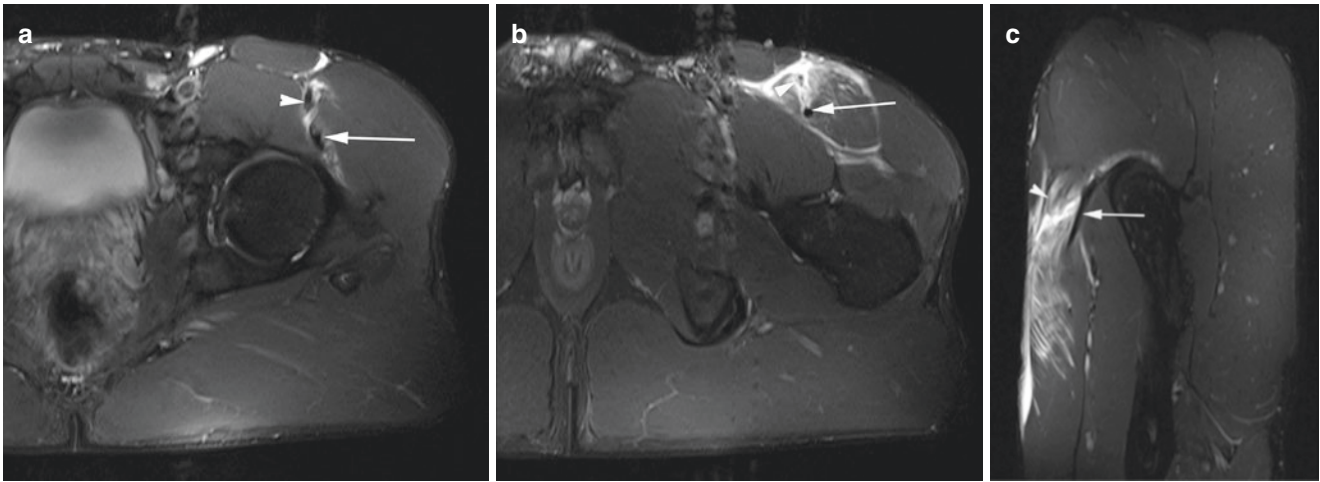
Myotendinous injury. A 23-year-old soccer player with acute anterior hip pain. Axial and sagittal T2FS MR images show (a) left proximal thigh intact indirect head tendon (arrow), direct head tendon (arrowhead), and muscle edema. (b) and (c) Inferior to (a) show intact indirect head tendon (arrow), torn direct head tendon (arrowhead), and extensive muscle disruption
